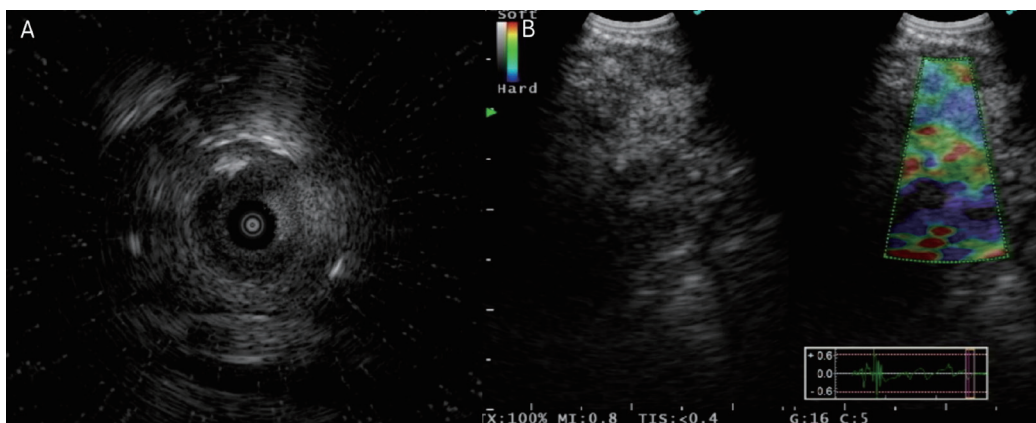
A. Endobronchial ultrasound (EBUS) revealed an ill-defined margin with heterogeneous echogenicity and airbronchogram. B. Real-time EBUS showed a mediastinal lymph node with homogenous echogenicity, irregular shape and predominantly blue under elastography.
